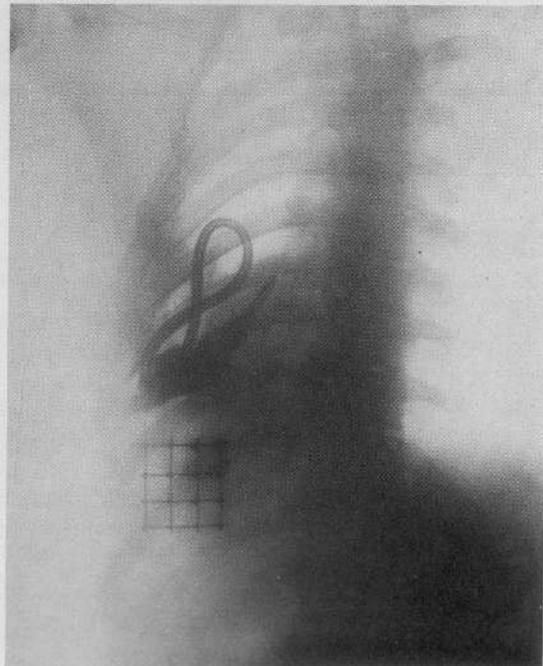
Roentgenogram of empyema with rubber catheter, estimating the size of the cavity. Wire localizer estimates distance of abscess from the skin.
